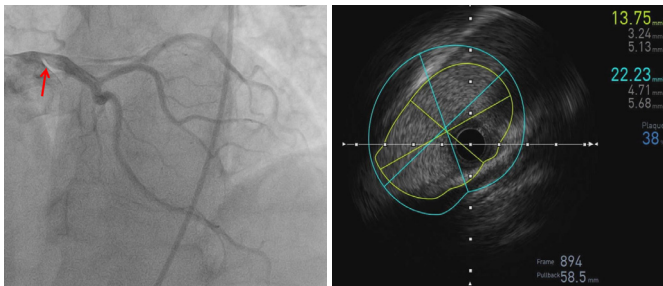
In the left figure, the red arrow shows the lesion at the origin and proximal of the left main coronary artery on coronary angiography. The figure on the right shows an intravascular ultrasonography image consistent with external compression in the left main coronary artery.
